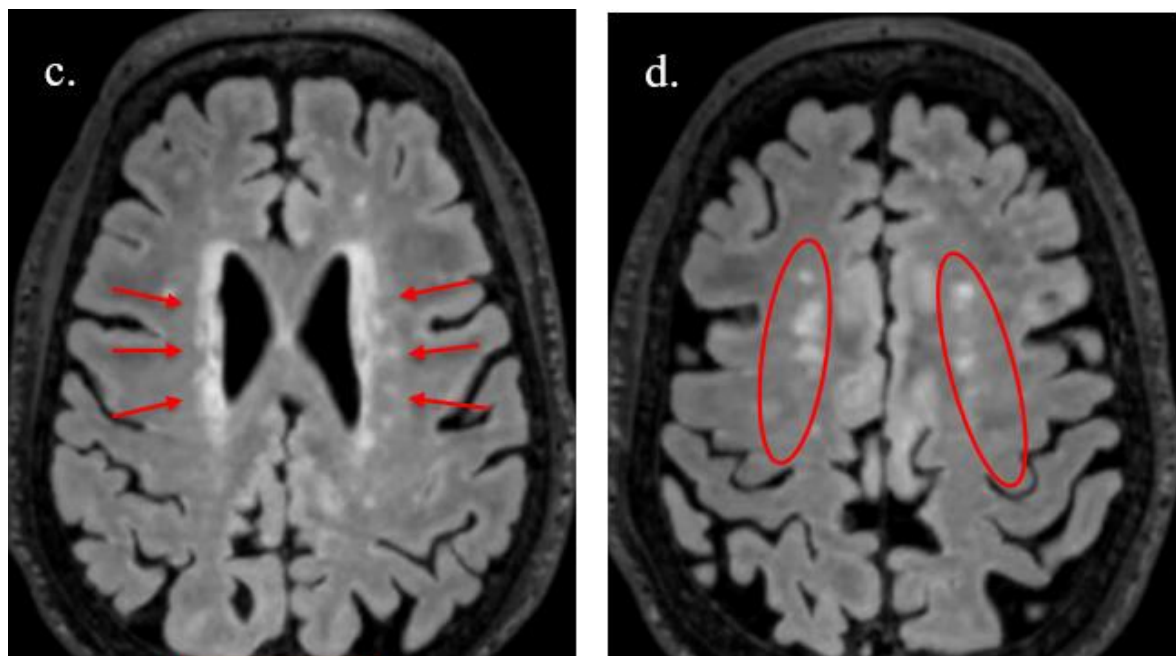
Cases of different distributions of moderate WMHs: (c) Moderate PV-WMH. (d) Moderate D-WMH. Case 1, a 72-year-old man with mild hypertension, FLAIR images showed partial confluence of WMH at the sites of the brain periventricle and deep regions.
